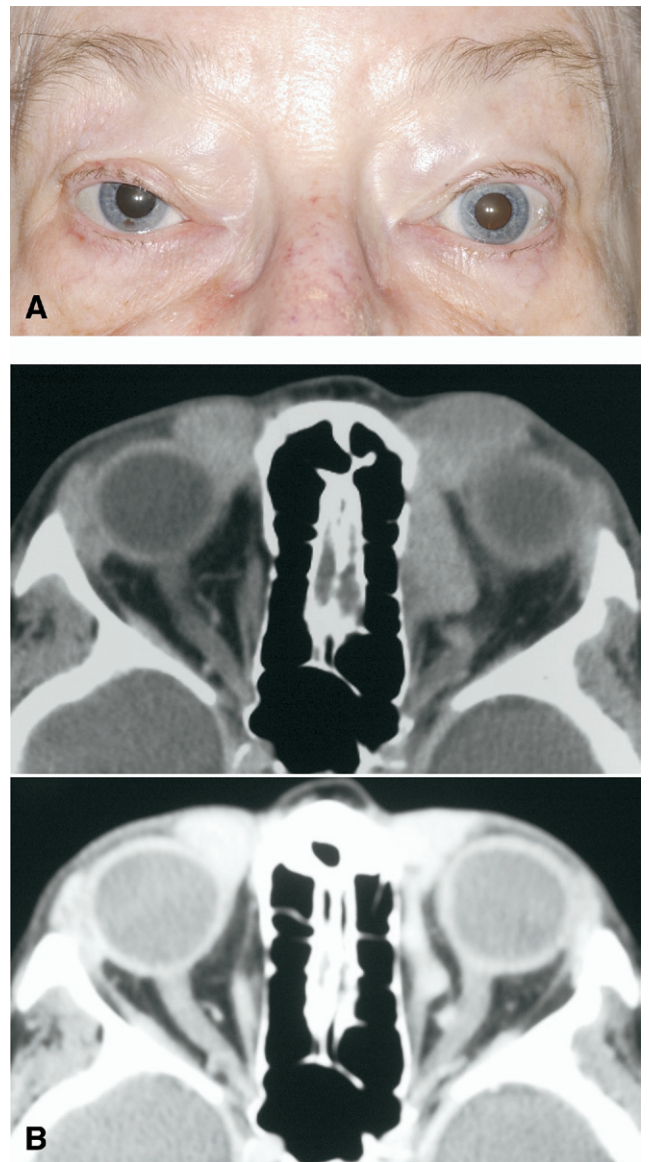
A, Photograph of an 84-year-old woman with bilateral proptosis and fullness to the supranasal eyelids. She was found to have bilateral salmon-colored conjunctival tumors in the supranasal fornix. B, Computed tomography scans showing bilateral solid orbital masses moulding to the globe supranasally.
